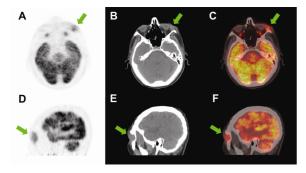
head ¹⁸F-FDG PET/CT transaxial PET (A, D), CT (B, E) and fused PET/CT (C, F) images show high ¹⁸F-FDG uptake area in the lateral side of the left orbital cavity (green arrows).
